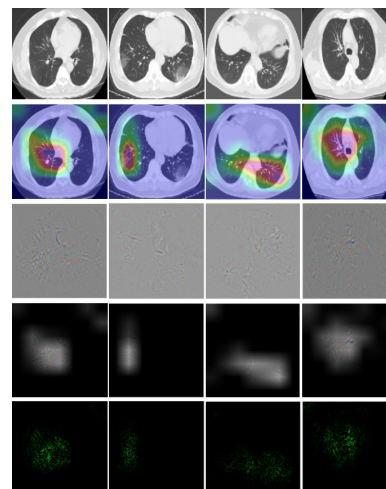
Sample chest CT images of COVID-19 cases from the test set and their associated critical features (e.g. ground-glass opacities and reticular pattern) identified by the proposed model.
